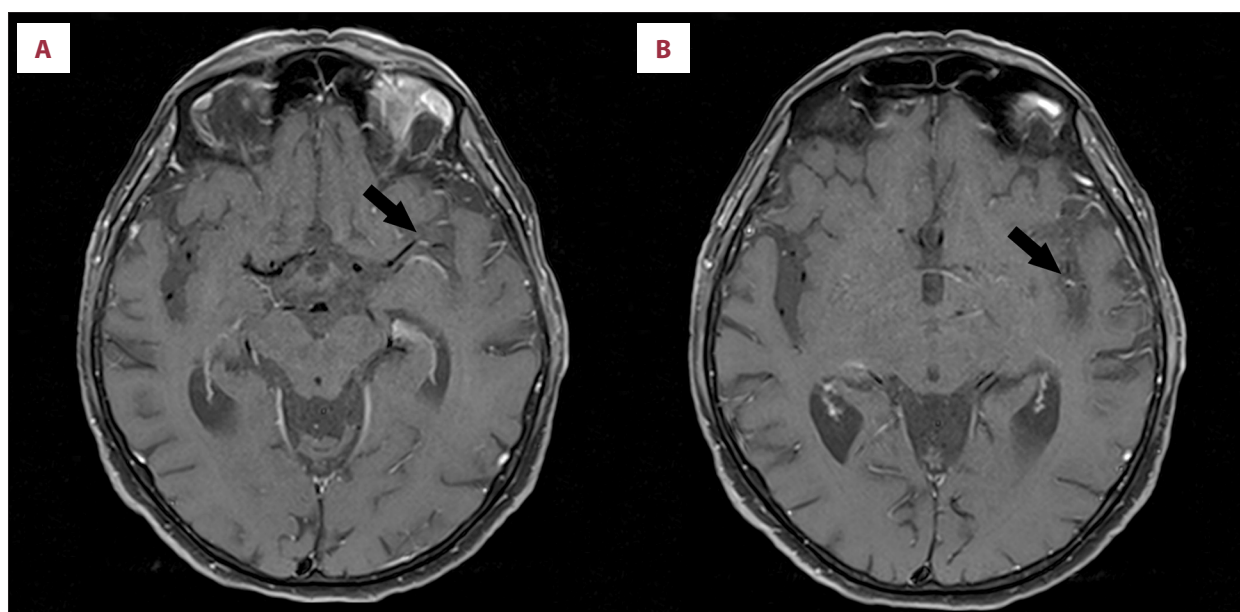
Contrast-enhanced magnetic resonance images showing enhancement of the left middle cerebral artery M2 segment (A) and M3 segment (B), suggestive of vasculitis.
